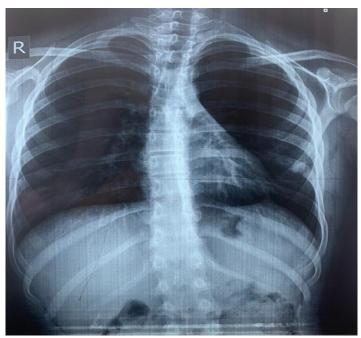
shows chest x-ray of the patient with penetrating cardiac injury after 14 days of surgery.
